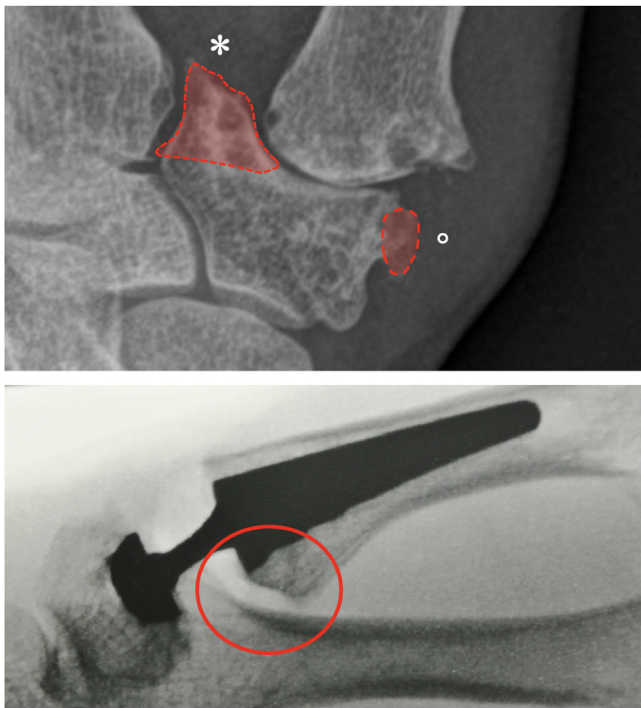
Top: radiographic anteroposterior view of the trapeziometacarpal joint with delineation of osteophytic enlargement of the medial intermetacarpal (*) and the lateral (°) horn of the distal articular surface of the trapezium. These should be removed. Bottom: lateral radiographic view after trapeziometacarpal total joint replacement demonstrating proper removal of the metacarpal volar beak.
